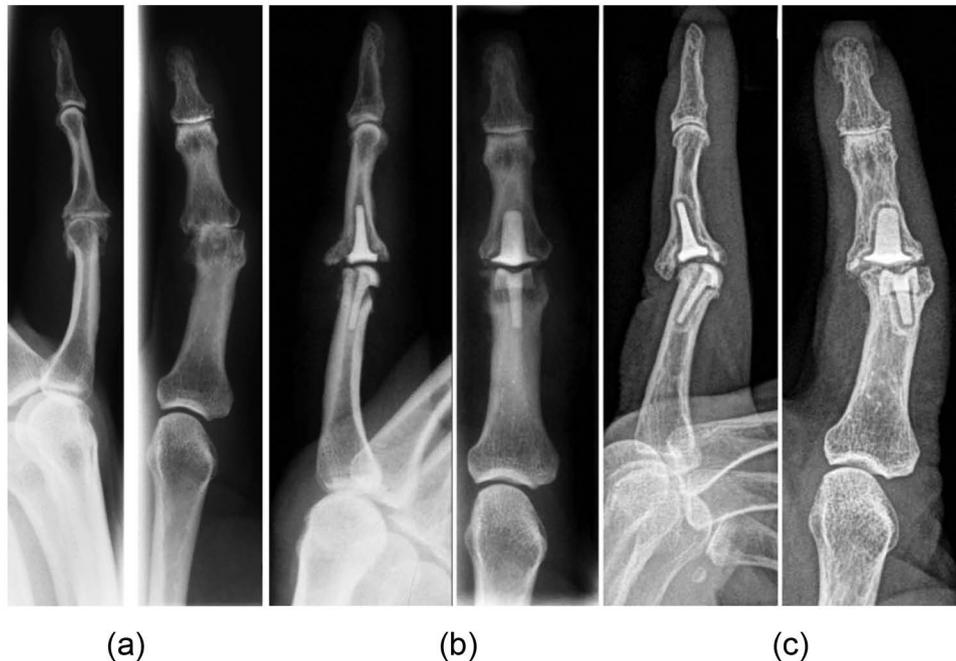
Pre-operative (a) and postoperative x-rays of a 64-year-old patient. Postoperative x-rays taken two days postoperatively (b) compared with the x-rays after a follow up of 8.5 years (c). At follow up a migration and rotation of the proximal and distal implant was observed.
